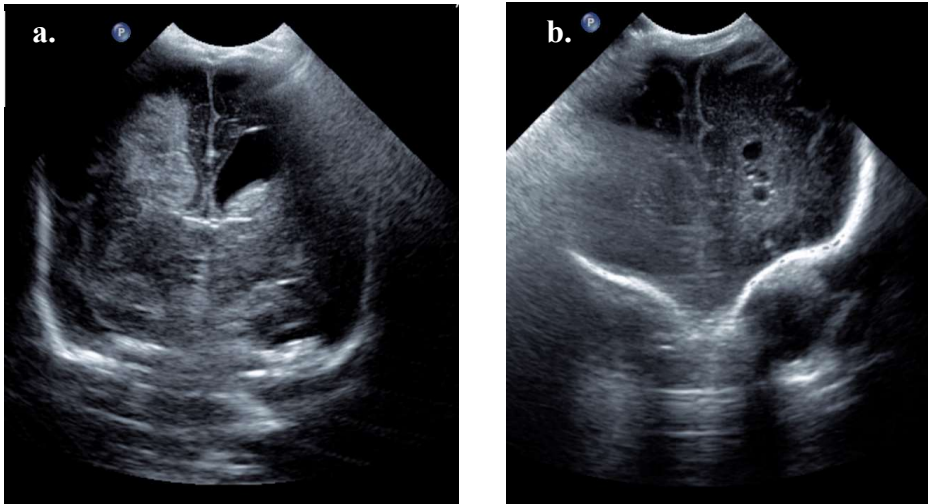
(A) Cranial ultrasound appearance of grade IV intraventricular haemorrhage and dilated ventricles and (B) left sided porencephalic cysts (anonymised images from Simpson Centre for Reproductive Health, Edinburgh UK)
